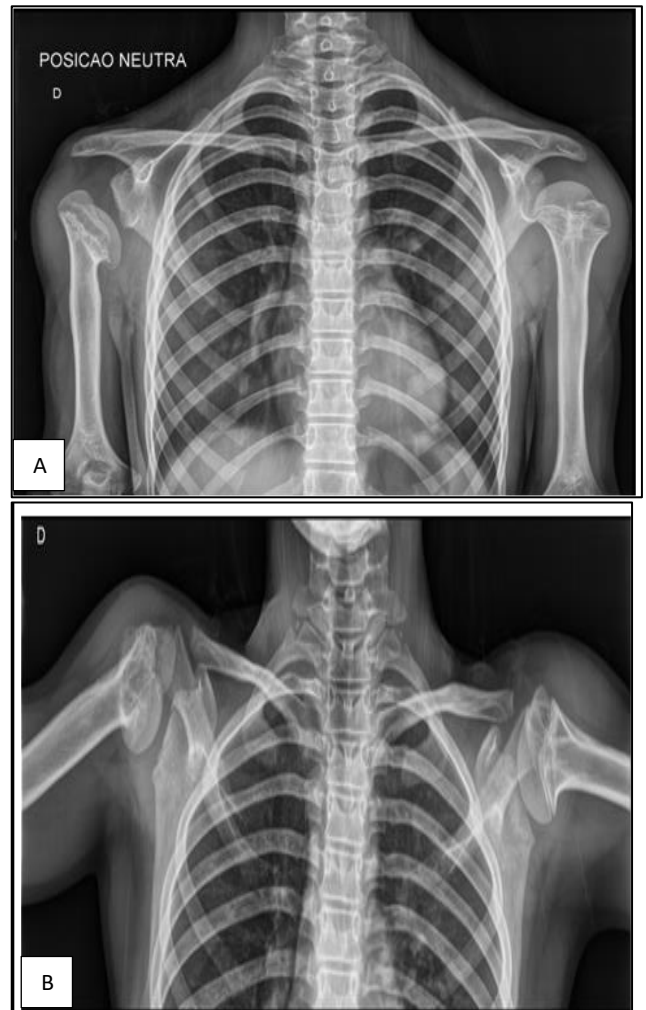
(A and B): Patient 5; antero-posterior radiographs of the shoulders in a neutral position and antero-posterior radiographs of the shoulders in abduction.
